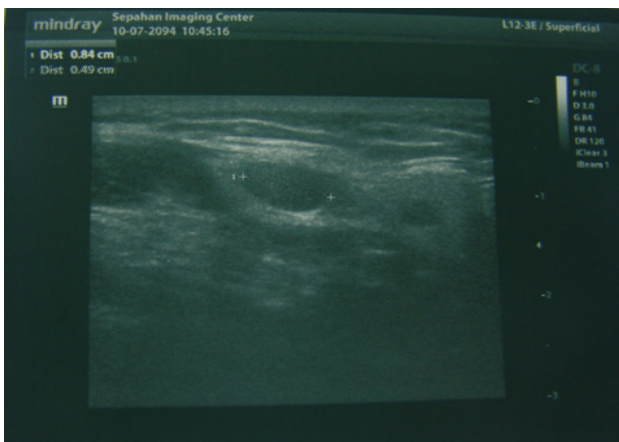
Sonography: Round and well-defined lesions in the right posterior auricular and behind the right parotid gland.
